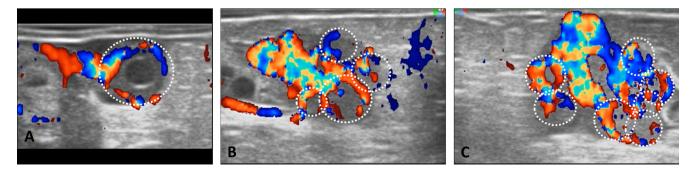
Ultrasonographic evaluation of the ovaries in superovulated ewes, approximately six days after ovulation. White dotted lines delineate corpora lutea (CLs). The three response patterns are presented: (A) low response, only one CL; (B) moderate response, four CLs; and (C) satisfactory superovulatory response, seven CLs.
